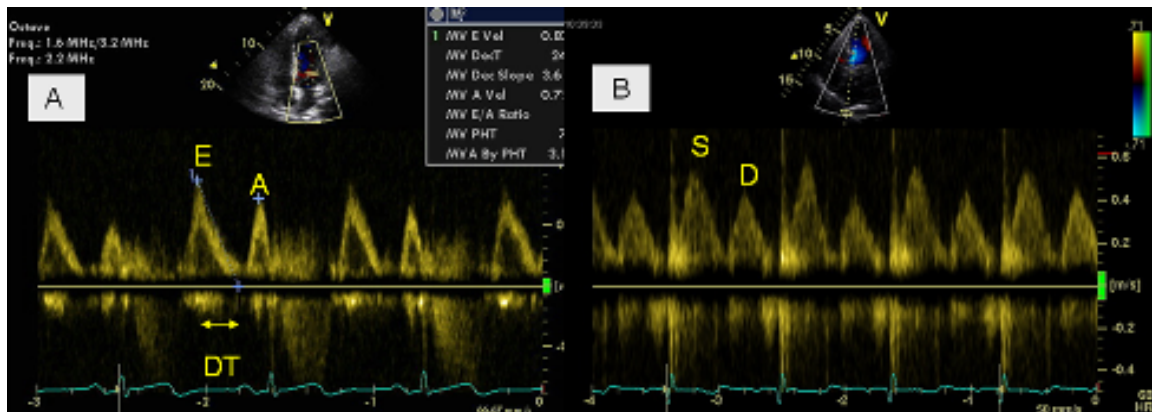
Echocardiography can be used to assess preload and volume status. (A) Mitral inflow velocity tracings show peak velocity [E] and deceleration time [DT] of the early inflow wave and peak velocity [A] of the late inflow wave at atrial contraction. (B) Pulmonary-vein Doppler image shows peak velocity of the systolic [S] and diastolic [D] forward spectrum.
